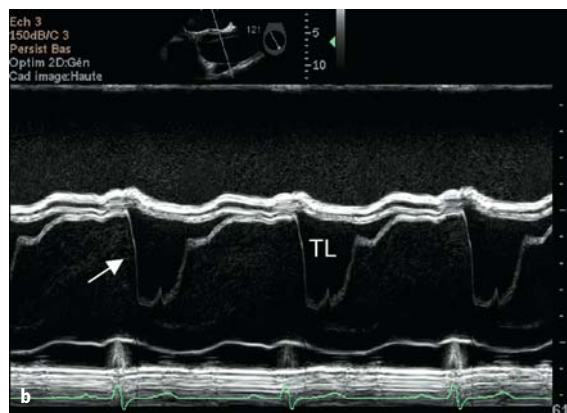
Dissection of the ascending aorta. a Longitudinal view with sinuous intimal flap (arrows). b M mode showing amplitude of displacement of the intimal flap. c M mode color Doppler image showing systolic flow into the true lumen (TL)
